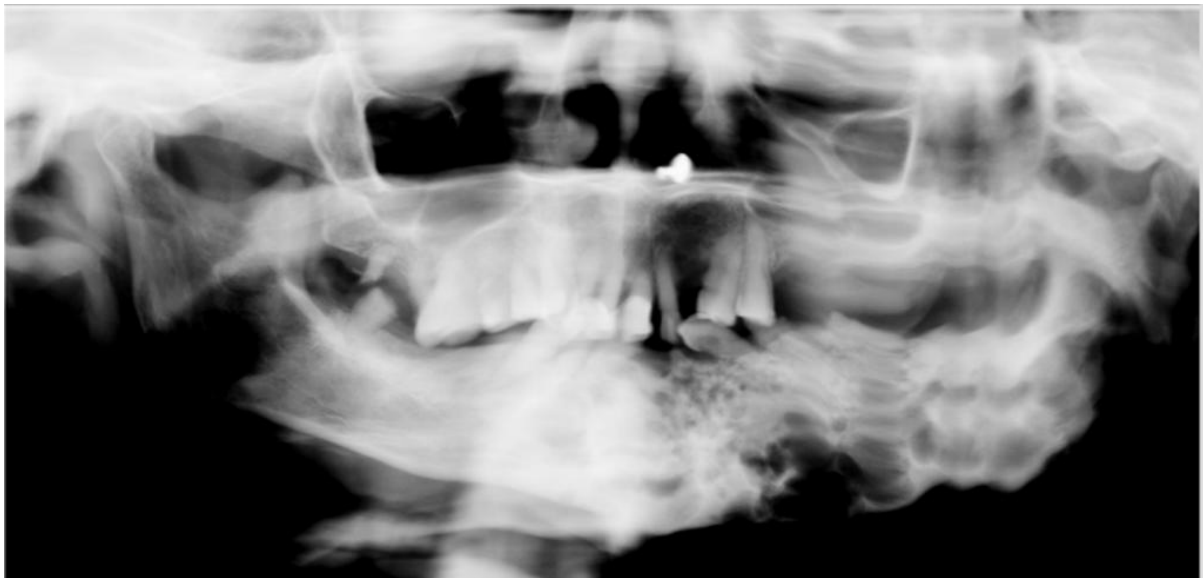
Panoramic radiograph shows ill-defined discrete radiolucent lesions in the mandible.
